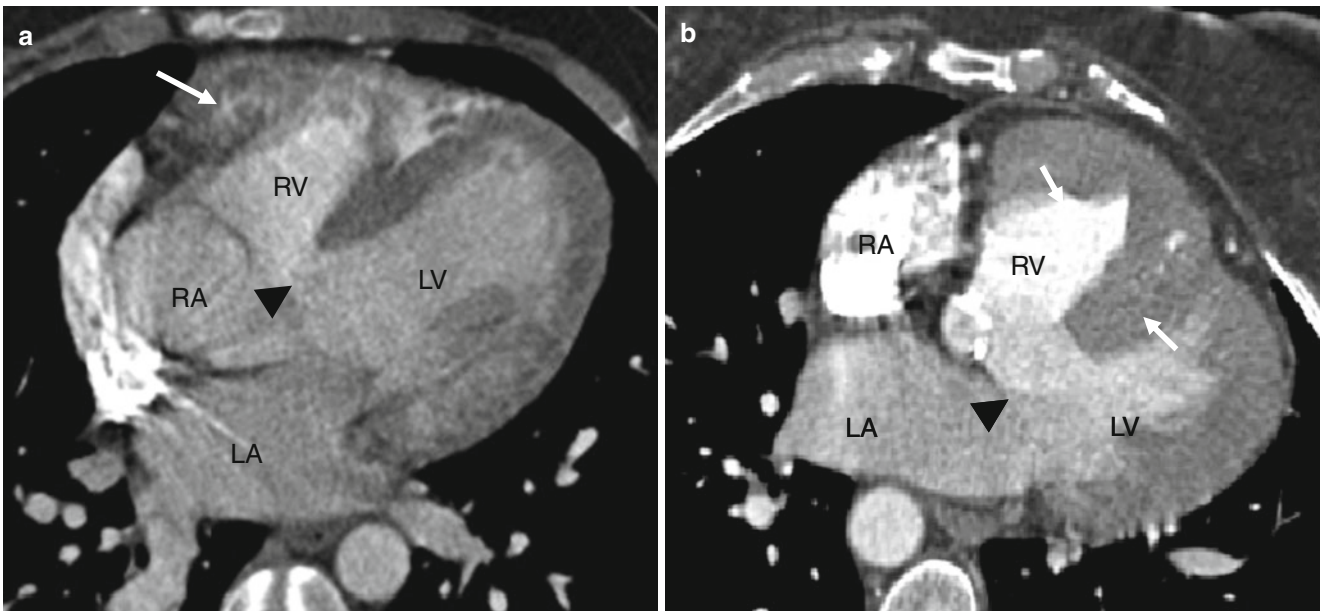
Type 2 ventricular septal defect (VSD). Panels (a) and (b) are axial computed tomography images from two separate patients with tetralogy of Fallot demonstrating perimembranous VSD (*black*
